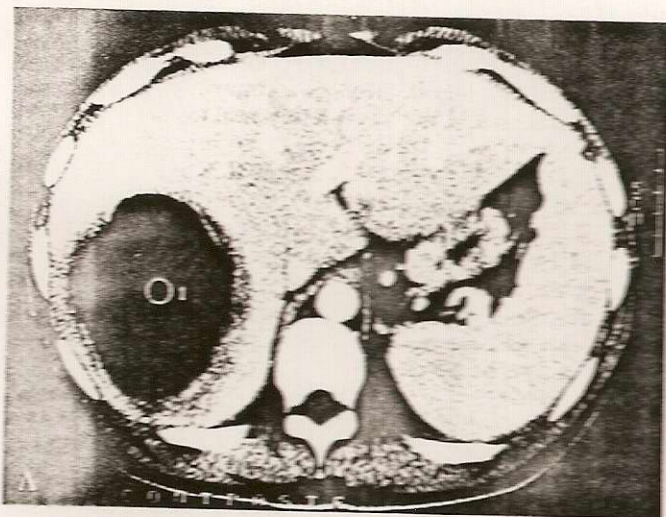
A) CT scan showing a unilocular abscess in the right lobe of the liver. B) Percutaneous drainage of the abscess.
